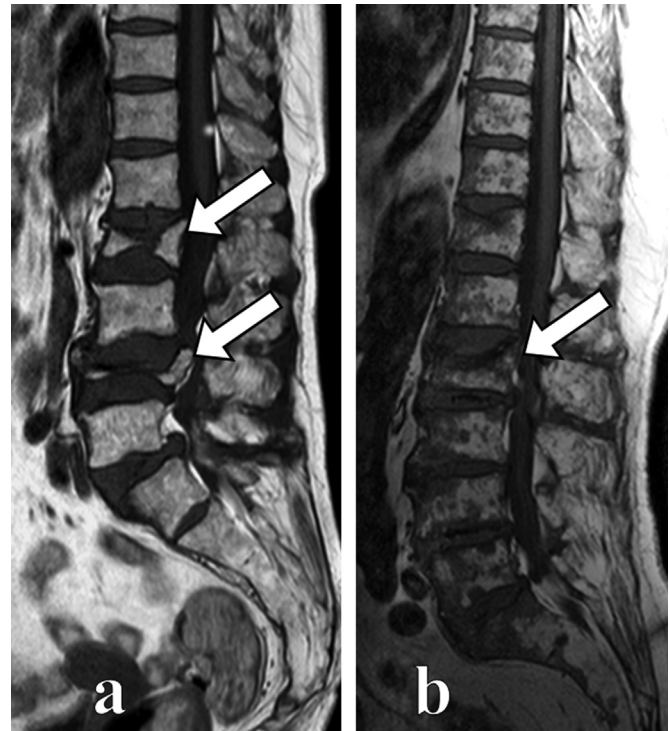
Examples of MRI used in the study. The arrows in image 'a' show lumbar vertebrae L1 and L3 with benign VCFs; the other lumbar vertebral bodies are normal. The arrow in image 'b' shows a malignant VCF in L2. Note that the other vertebral bodies without fracture of case 'b' have heterogeneous signal intensity representing foci of bone metastasis.
